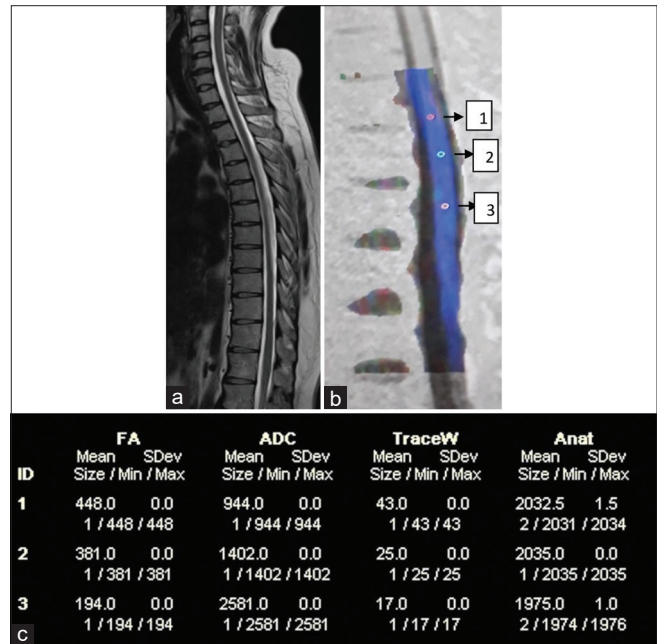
(a) Magnetic resonance imaging T2-weighted sagittal image in traumatic injury patient showing normal signal intensity of the spinal cord. (b) Diffusion tensor imaging image showing placements of three regions of interest. (c) Chart showing reduced fractional anisotropy and raised apparent diffusion coefficient values in the cord despite normal conventional magnetic resonance imaging
